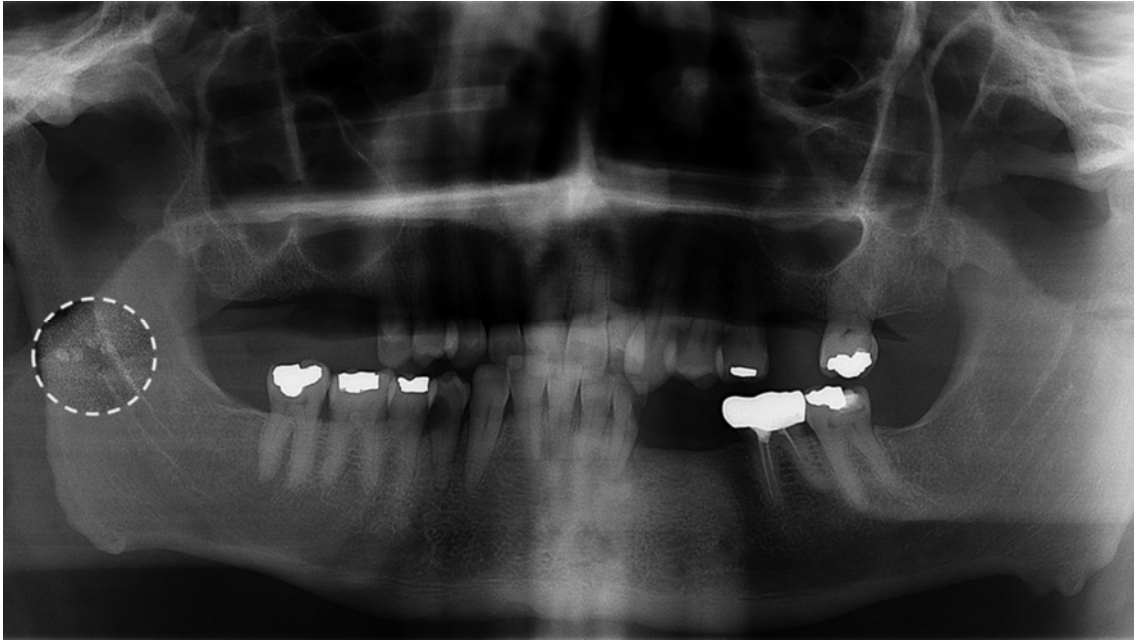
Panoramic radiograph of Case 1 showing small speck-like calcifications overlying the right ramus (encircled).
